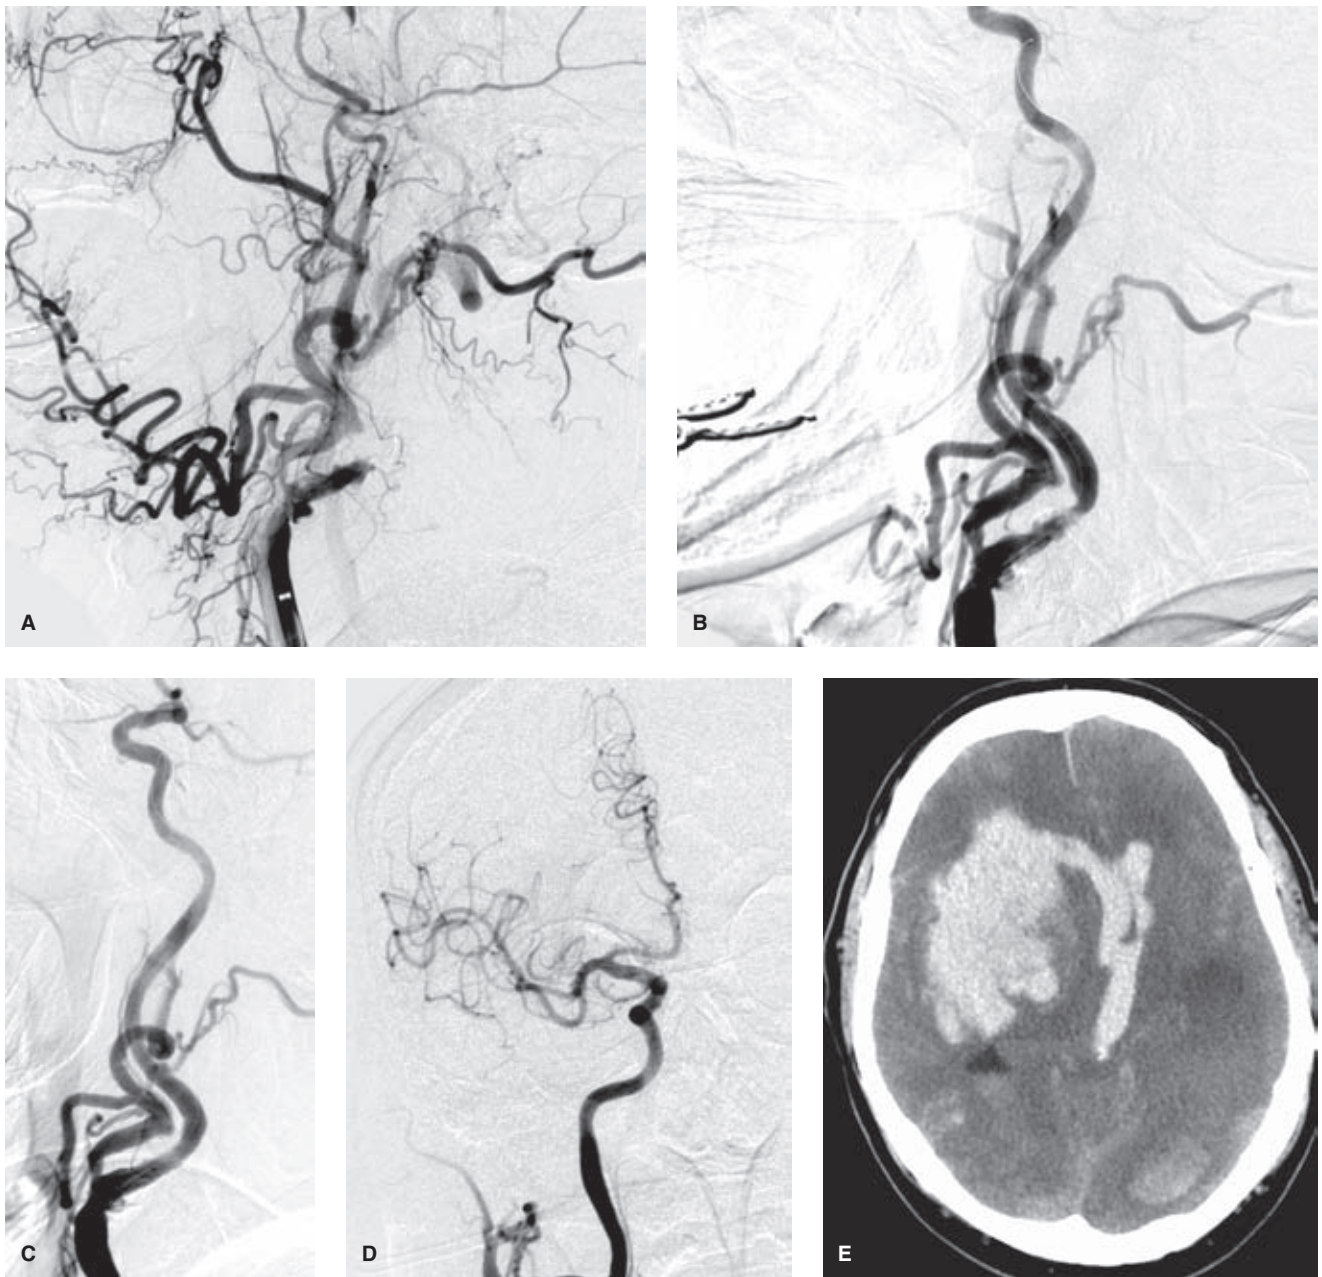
(A–E) Catastrophic outcome following a successful angiographic procedure. An elderly patient presented with an NIHSS score >20 and evidence of both infarcted tissue and extensive penumbra in the right hemisphere on CTP. The decision to treat him was not undertaken with a great deal of optimism. The right common carotid artery injection (A) showed complete occlusion of the right internal carotid artery with faint distal reconstitution at the cavernous level via ophthalmic and lesser collaterals, but poor intracranial collateral flow. An angioplasty (B) of the proximal right internal carotid artery was initially successful, but progressed to complete occlusion soon thereafter. A loading dose of eptifibatide was administered and the right internal carotid artery was stented (C) with a satisfactory appearance. The intracranial circulation was then revascularized (D) using a combination of balloon angioplasty (Hyperform), MERCI, and Penumbra devices. The patient's status did not improve dramatically following the procedure and the next day his condition deteriorated precipitately with massive hemorrhage evident on CT (E). The possible explanations for this hemorrhage are manifold and possibly interactive. These include overly aggressive antiplatelet measures prompted by the necessity for the stent, microwire perforations during the intracranial manipulations, or reperfusion of already infarcted tissue.
